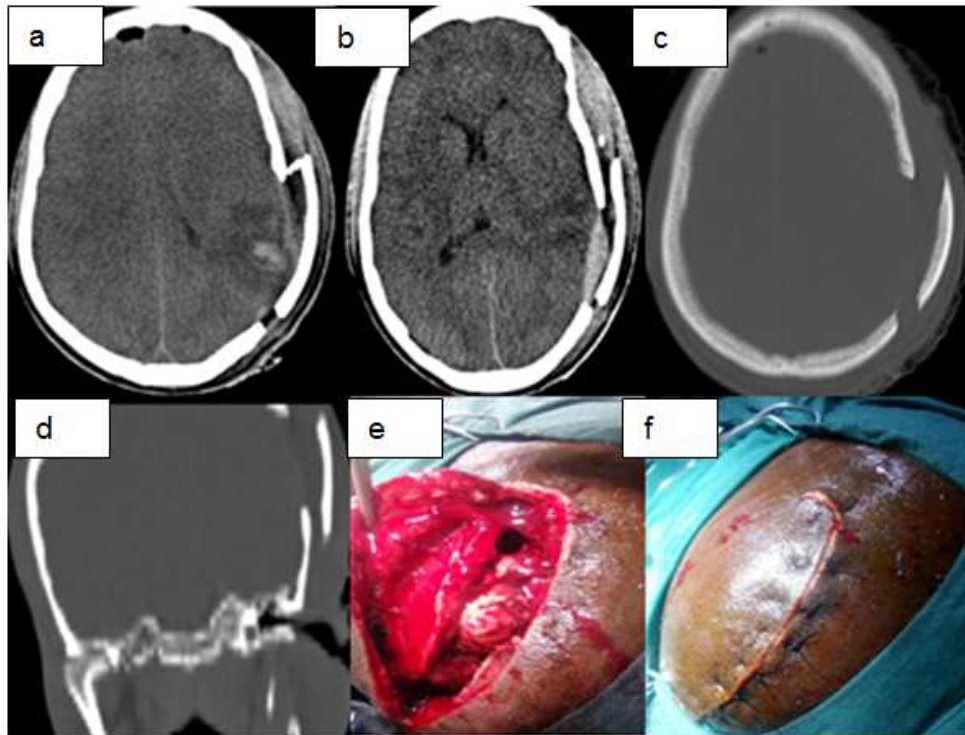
Showing CT Scan (a -d) and intraoperative images (e and f) of Case 2.
